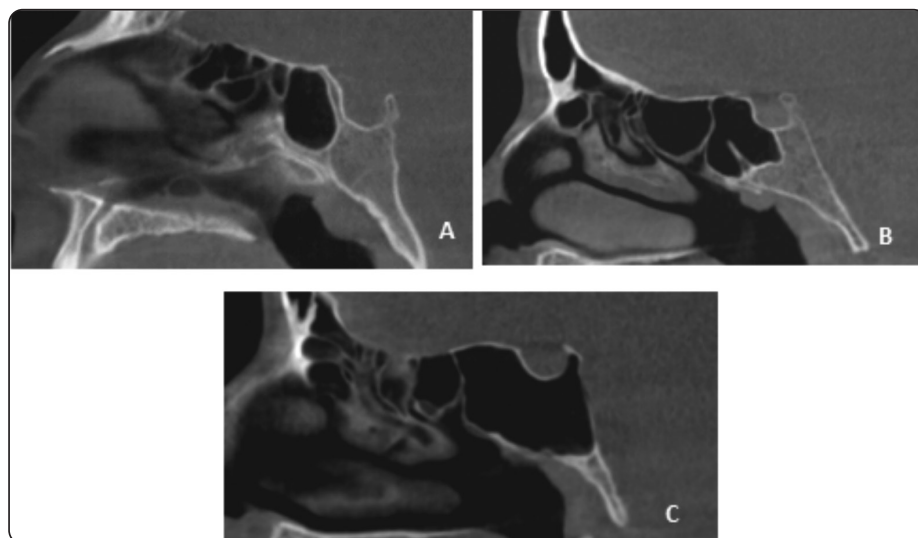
Sagittal cuts of CBCT showing types of SS pneumatization in relation to the sella turcica: A: presellar type (Type II), B:sellar type (Type III) and C: post sellar type (Type IV).
